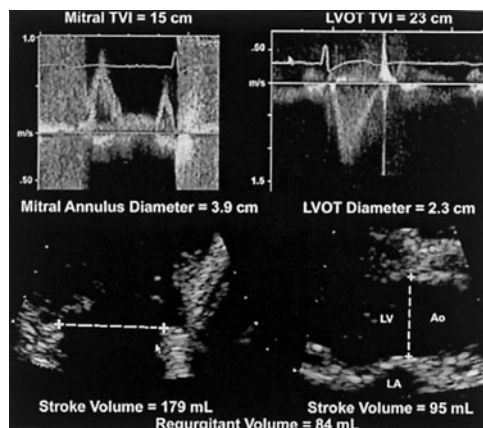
Quantitative Doppler assessment of mitral regurgitation (MR) based on stroke volume measurement using the annular diameter to calculate the annular area and its product with the pulsed-wave Doppler as the stroke volume traversing the specific annular area. The left part of the figure measures the mitral stroke volume (179 mL/beat), whereas the right side measures the aortic stroke volume (95 mL/beat). Thus the regurgitant volume is calculated as the difference between mitral and aortic stroke volumes, or 84 mL/beat.
